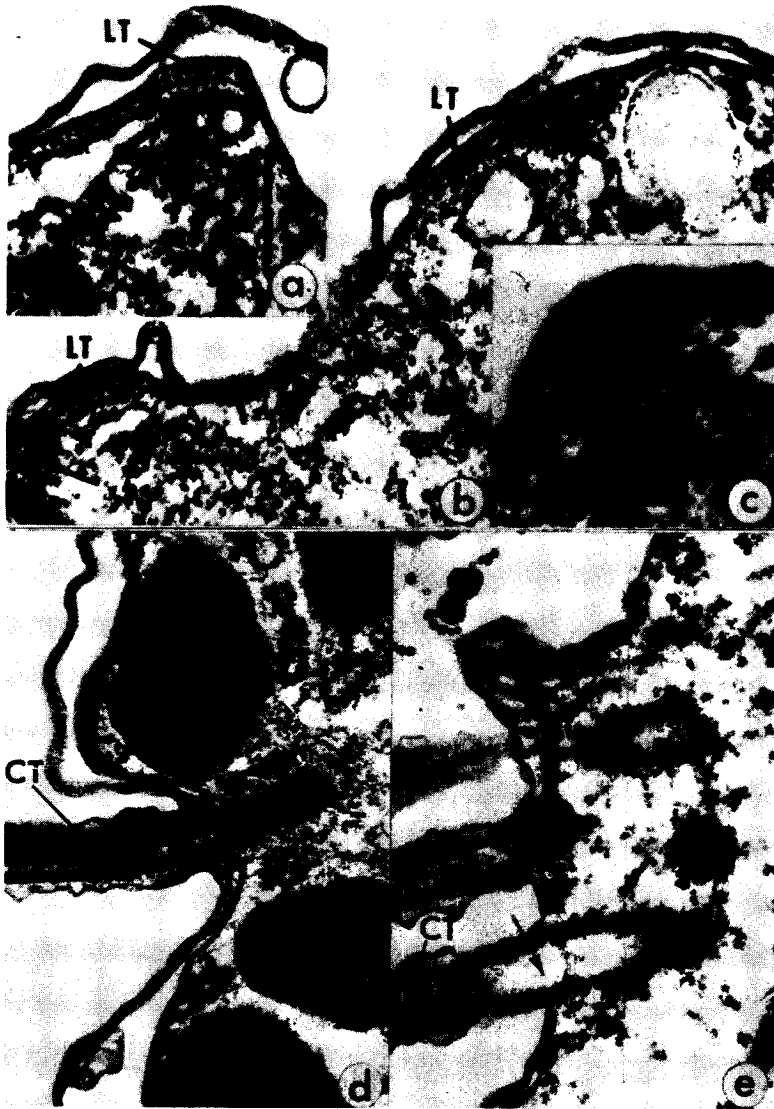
The effects of pressure on the fine structure of *Tetrahymena pyriformis*. a, Cross section through a cell at atmospheric pressure. The longitudinal microtubules (LT) are shown just below the surface (X 72,000). b, Section through a cell subjected to 7,500 p.s.i. for 2 minutes. There is an increased amount of granular material (arrows) in the region normally containing longitudinal microtubules (LT) (X 72,000). c, Cross section through a cell subjected to 7,500 p.s.i. for 2 minutes. The longitudinal microtubules show some disruption. Both normal and disrupted (arrows) microtubules are evident (X 144,000). d, Cilium from a control nonpressurized *Tetrahymena*. The central tubules (CT) of the cilium appear unaltered (X 52,000). e, Section through surface of a *Tetrahymena* which was subjected to a pressure of 10,000 p.s.i. for 10 minutes. A longitudinal section through the cilium shows breakdown (arrow) of the central ciliary microtubules (CT). Swelling of the ciliary shaft appears to be at the junction of the basal body (arrow) (X 52,000). (From Kennedy and Zimmerman [16].)
